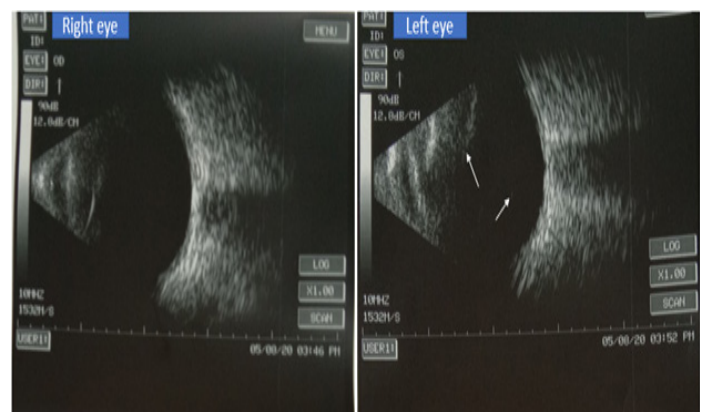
Ultrasound B scan of both eyes. The right eye has echo free vitreous cavity and left eye has dot like hyperreflectivity in vitreous cavity (white arrow)
